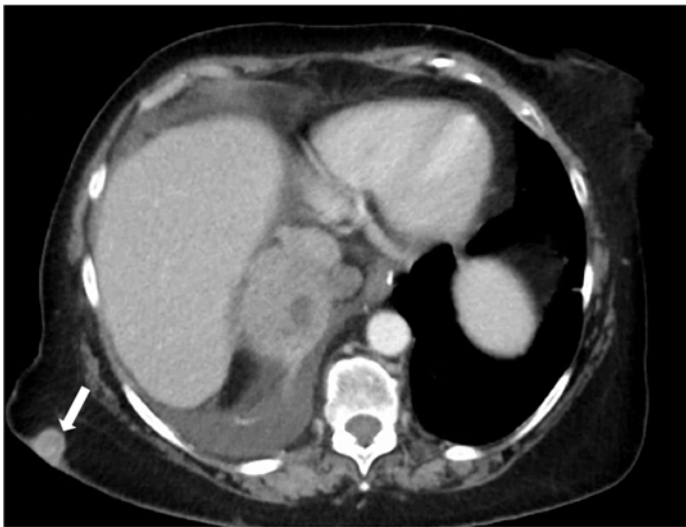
Abdominal CT scan with intravenous contrast. White arrow showing subcutaneous carcinoid metastasis. A large right pleuro-parenchymal lung mass and small right pleural effusion can also be appreciated.
